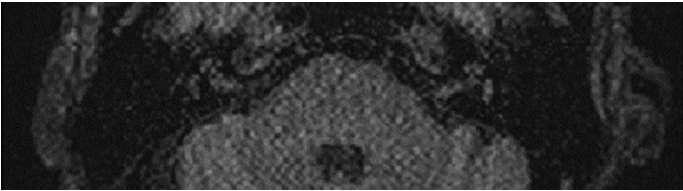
Images of axial 3D-FLAIR before gadolinium injection in the tympanum.
